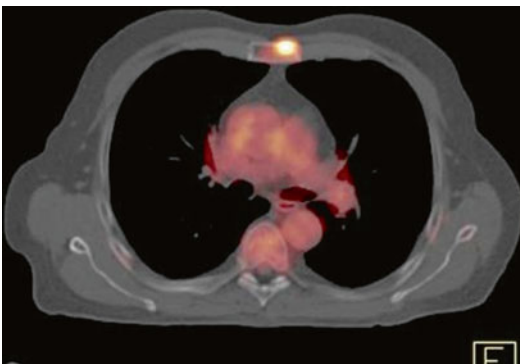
Sternum lesion with no corresponding CT findings
